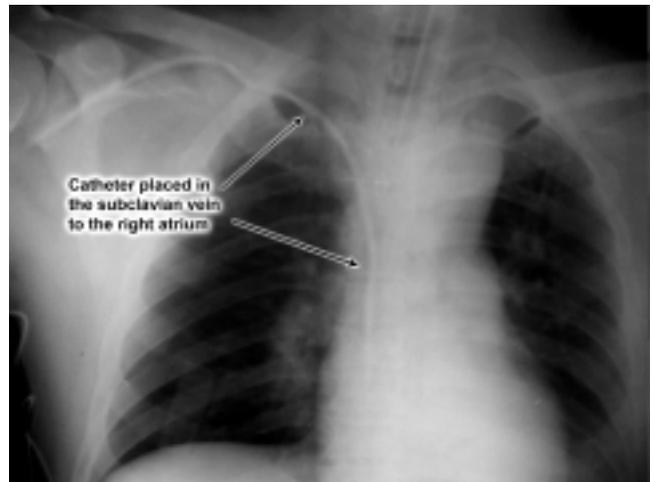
Confirmation by radiographic imaging of the placement of the catheter in the right subclavian vein down to the right atrium of the heart.
